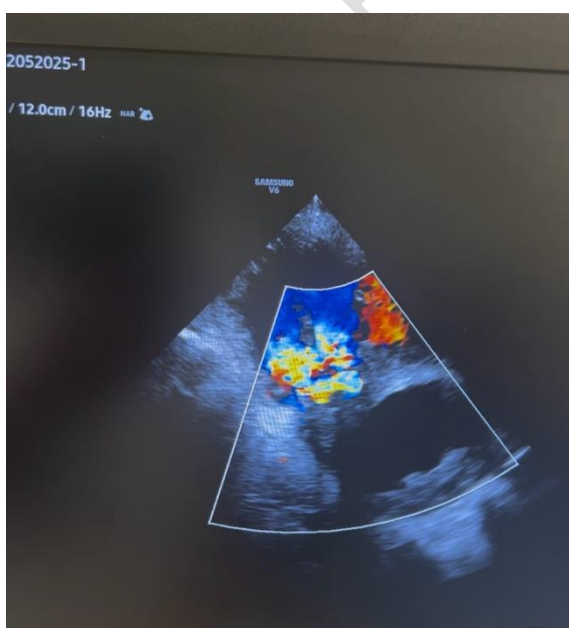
Transesophageal echocardiography showing the septo-apical VSD associated with a pseudoaneurysm bounded by a membrane, resulting in a tortuous course of the shunt on color Doppler
